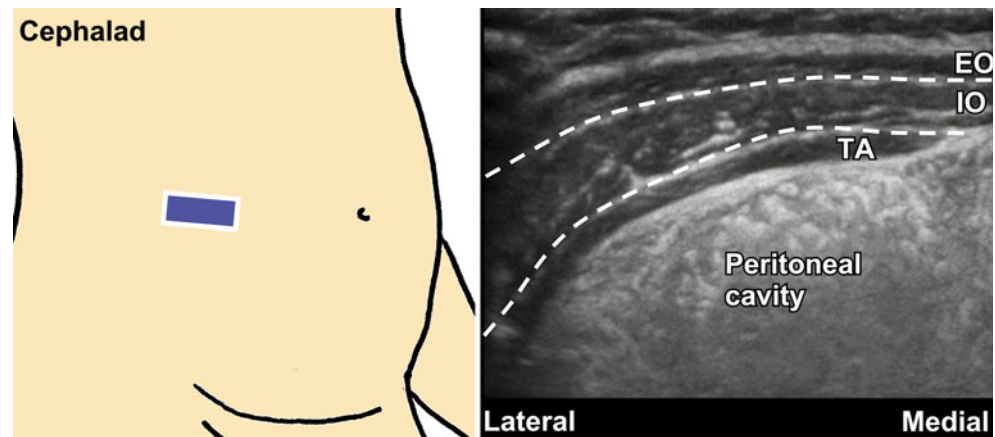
Ultrasound images of the abdominal muscles and transversus abdominis plane. *EO* external oblique, *IO* internal oblique, *TA* transversus abdominis muscle
